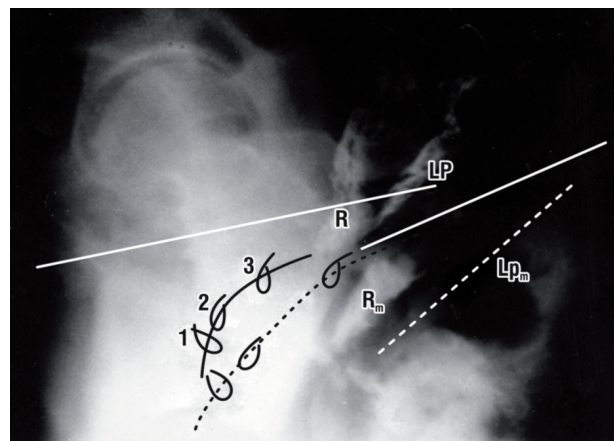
Upper figure X-ray proof of an external musculoelastic mechanism pulling open the posterior urethral wall. Micturition (broken lines) X-ray superimposed on resting X-ray (unbroken lines). Clips have been applied to the anterior vaginal wall, ‘1’, mid-urethra, ‘2’ bladder neck, ‘3’ bladder base. Note downward/backward displacement of clips ‘1,2&3’. The levator plate (LP) and rectum (R) are angulated downwards. Downward movement of clip ‘1’ may indicate active contraction of the lower level muscles of the pelvic floor, such as bulbocavernosus and ischiocavernosus, opening out the posterior wall of the distal urethra. Clips 1 & 2 also indicate the movement of the distal half of urethra which is closely attached to the vagina. The broken lines and the subscript ‘m’ indicates the position of the LP and R during micturition. Vascular clips on anterior vaginal wall were stretched apart backwards and downwards. Intraabdominal forces are said to cause downward movement, but they could never initiate the backward stretching seen in figure 2. Only a muscle contraction can achieve this.
